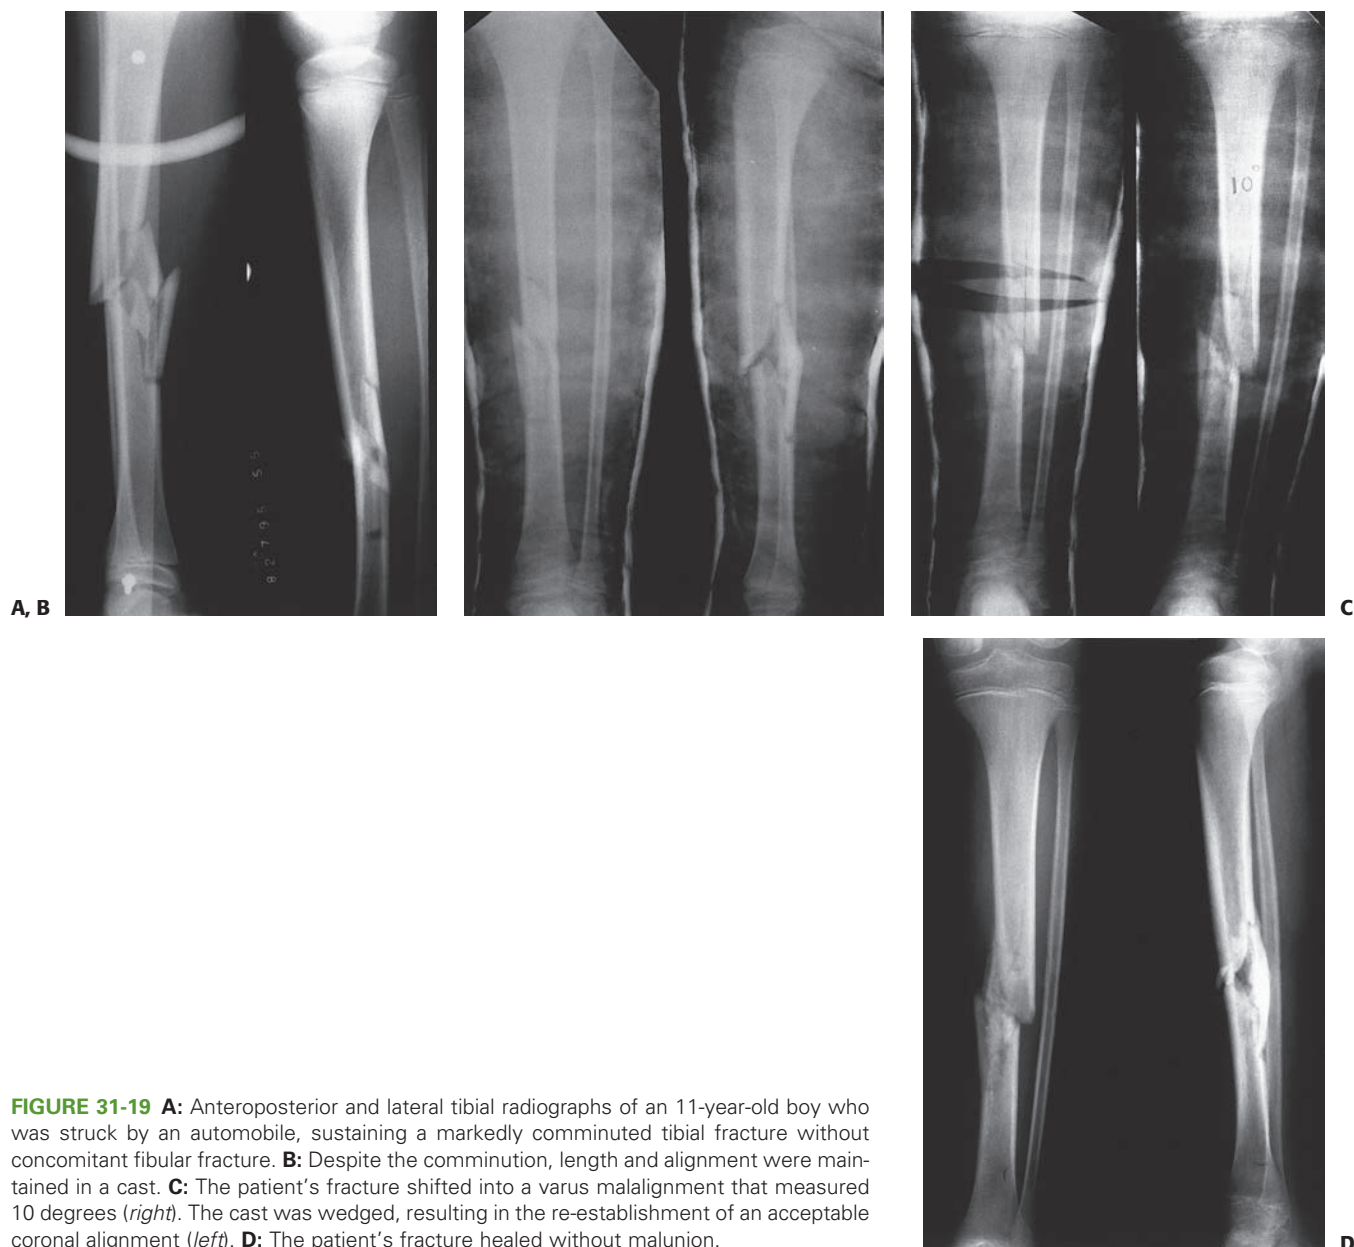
A: Anteroposterior and lateral tibial radiographs of an 11-year-old boy who was struck by an automobile, sustaining a markedly comminuted tibial fracture without concomitant fibular fracture. B: Despite the comminution, length and alignment were maintained in a cast. C: The patient's fracture shifted into a varus malalignment that measured 10 degrees (*right*). The cast was wedged, resulting in the re-establishment of an acceptable coronal alignment (*left*). D: The patient's fracture healed without malunion.
